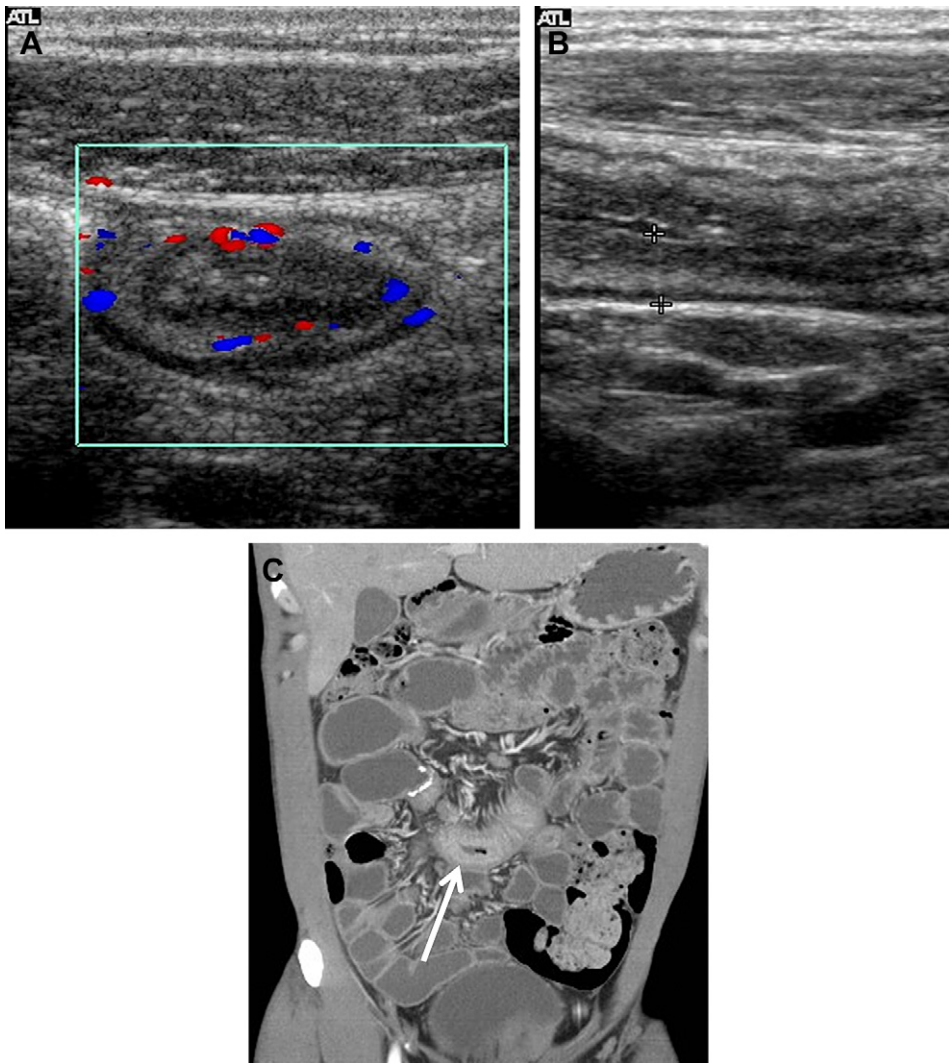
Recurrence at the neoterminal ileum. (A) Cross section of the neoterminal ileum demonstrating bowel wall thickening measuring 7 mm and Doppler signal consistent with inflammation. (B) Longitudinal view of the neoterminal ileum; note preservation of bowel wall layers with bowel wall thickening (*between calipers*). (C) CT enterogram confirming findings of recurrence at the neoterminal ileum (*arrow*).
